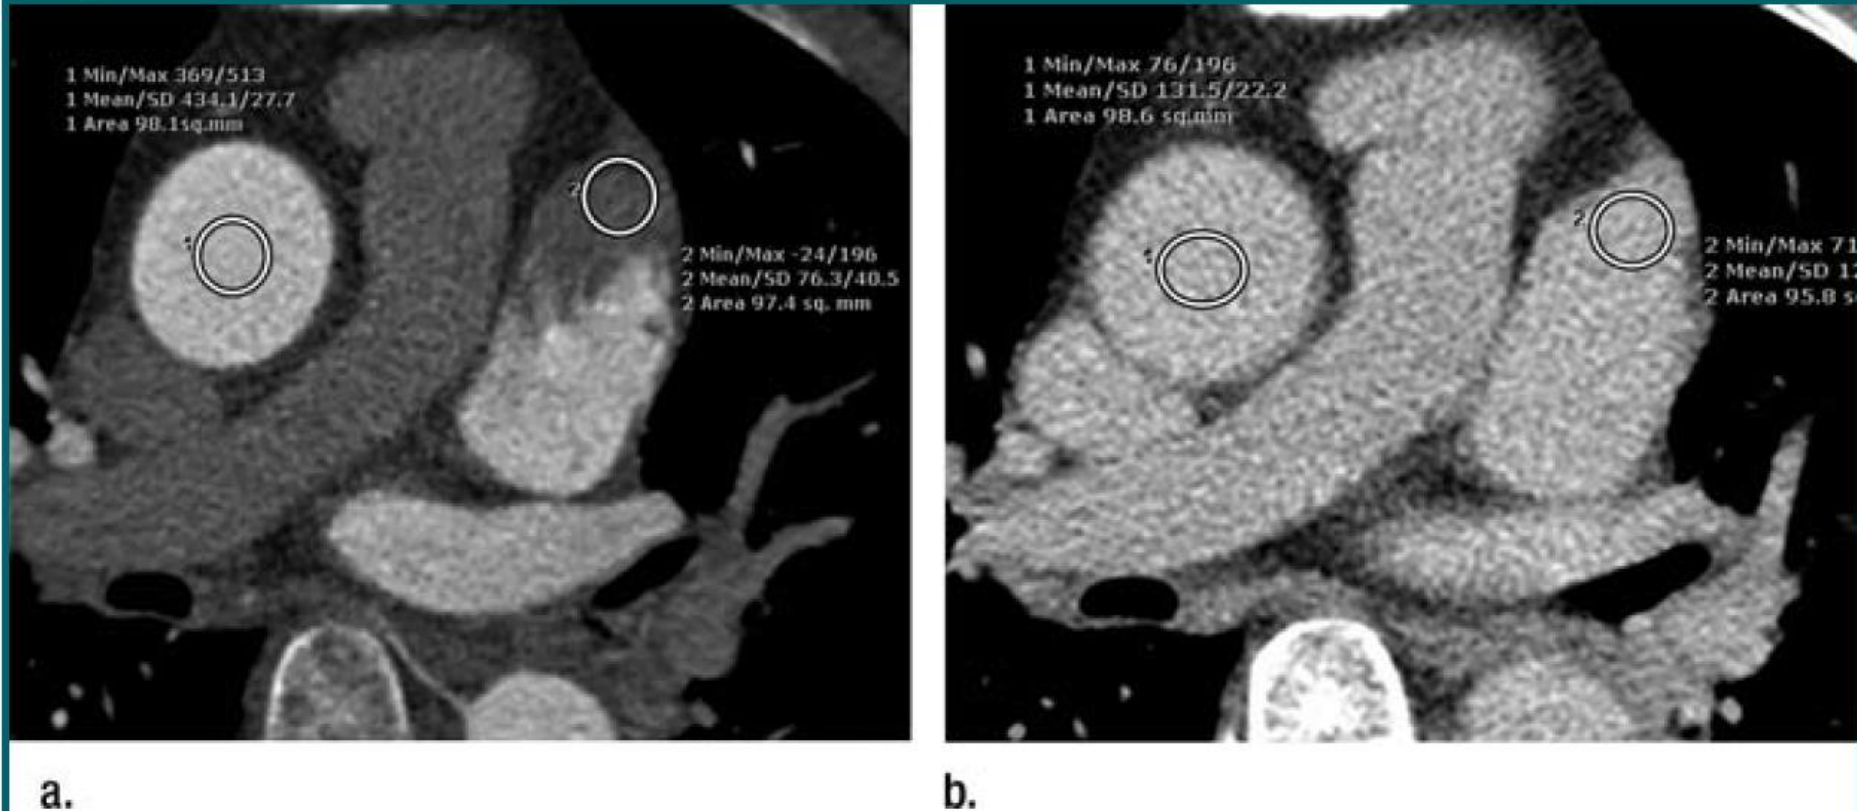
Axial cardiac CT angiographic images of thrombus and circulatory stasis obtained in 67-year-old man for calculation of (a) mean LAA/AA_E and (b) mean LAA/AA_L at quantitative analysis. Two regions of interest (regions 1 and 2) of approximately 10 mm² are placed inside the filling defect in the LAA seen on the early-phase images and in the ascending aorta of the same section.
